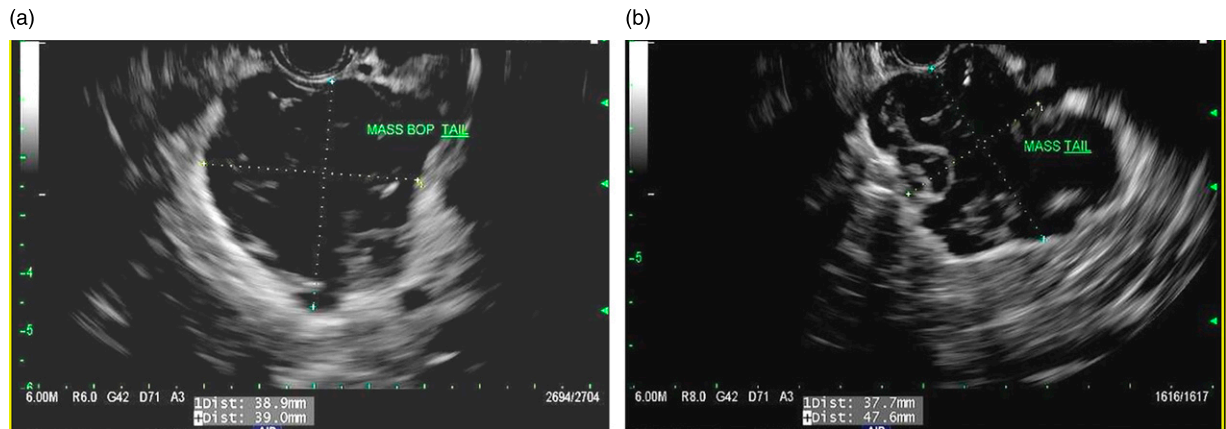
(a) and (b) Endoscopic ultrasound images of the large pancreatic mass involving the body and tail. The complex cystic nature is appreciated with the overall hypoechoic appearance of the mass with multiple scattered hyperechoic foci corresponding to the mucinous nature of colloid adenocarcinoma.
